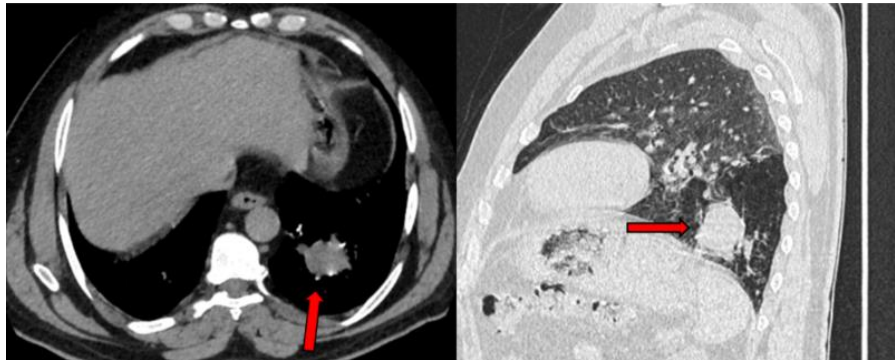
Axial non-contrast chest CT image (mediastinal window) demonstrating a well-defined, lobulated soft-tissue mass in the posterior basal segment of the left lower lobe. The lesion has smooth margins without associated pleural effusion or mediastinal lymphadenopathy.
